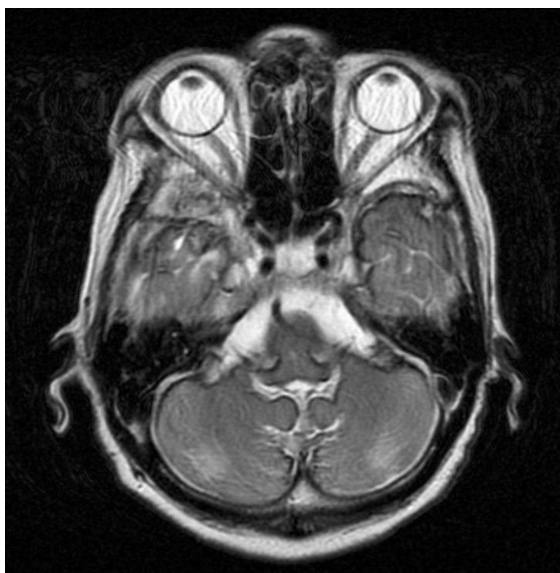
MRI of the brain showing superficial siderosis after VP shunt (T2-weighted sequence)
